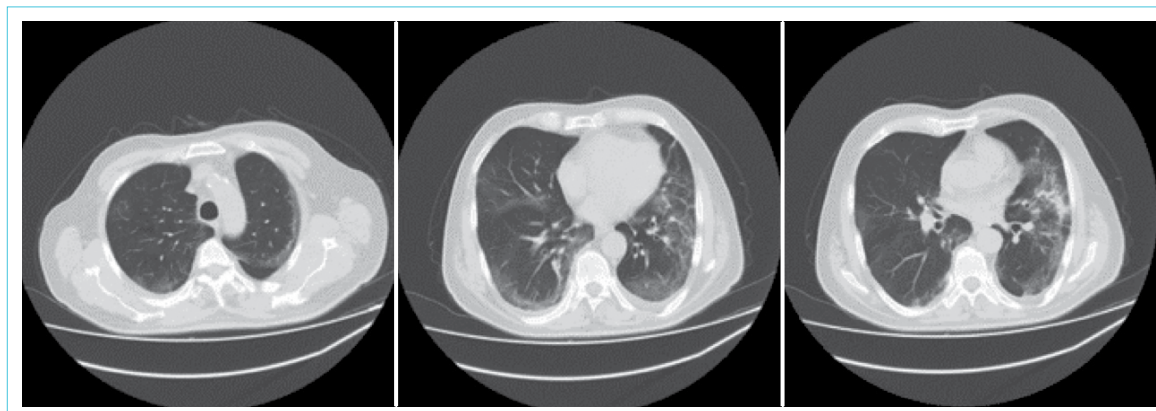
Chest tomography images of the patient; the typical appearance of consolidation, bilateral, peripheral and basal in the distribution of ground-glass opacity and crazy paving appearance in CT.
